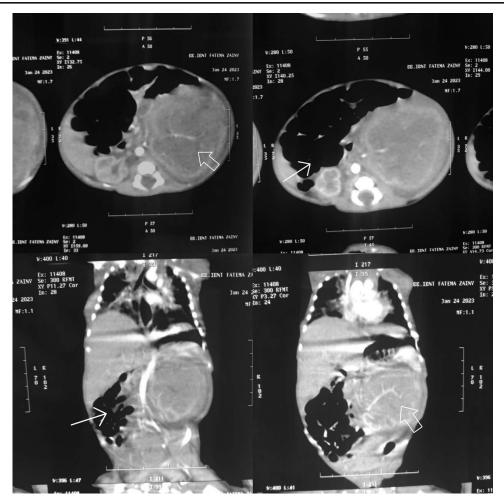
Computed tomography scan revealed a mass lesion (wide arrow) protruding from the upper part of the left kidney's parenchyma showing a broad, hypodensified center with a strongly reinforced periphery and numerous vascular-arterial extensions within it. In its upper anterior part, it contains several cystic formations and strongly pushes the left kidney, intestinal loops, and adjacent anatomical elements (narrow arrow). It appears isolated from the abdominal aorta and measures about (5 × 4.8 × 6.4 cm). A small amount of free fluid is seen in the pelvis.
